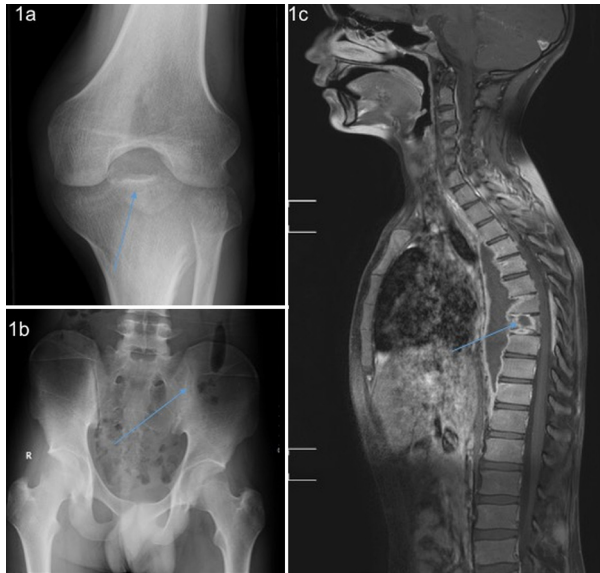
Three patients with different osteoarticular manifestations of tuberculosis. (a) Anteroposterior radiograph of the left knee showing widened intercondylar notch of femur along with small erosion in the tibia (arrow). (b) Anteroposterior radiograph of the pelvis showing reduction of the left sacroiliac joint space with sclerosis involving both iliac and sacral sides, suggestive of sacroiliitis. (c) Post-contrast T1-weighted sagittal images of the spine showing a large paravertebral collection from D4 to D10 levels along with spondylodiscitis at the D8-D9 level and abscess formation within the D8 vertebra.
